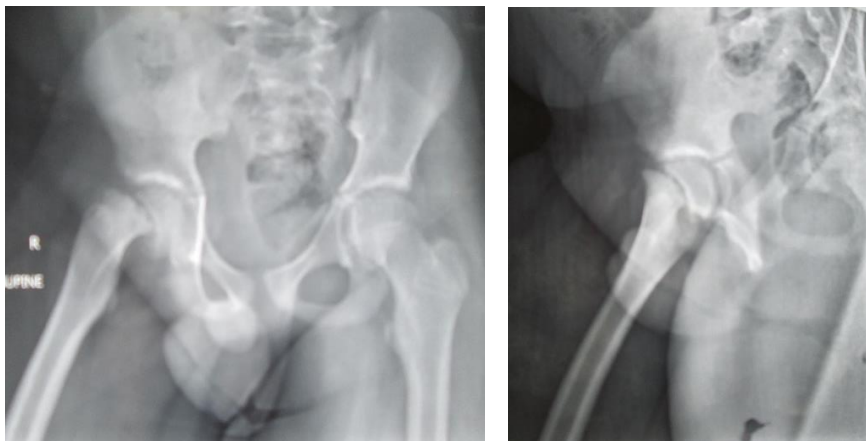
Pelvis and Frog leg lateral x-ray views showing severe SUFE of the right hip.
